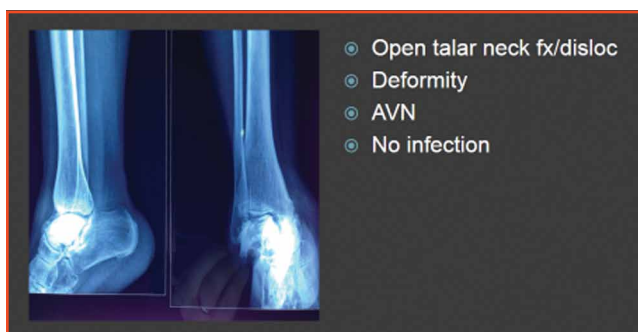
Case 2: Radiographs showing open talar neck fracture-dislocation.
